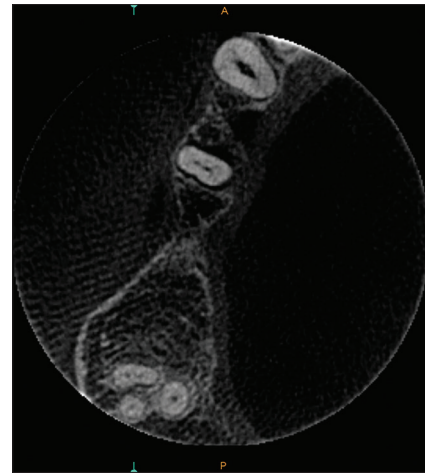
Cone beam computed tomography image showing maxillary third molar with MB2
